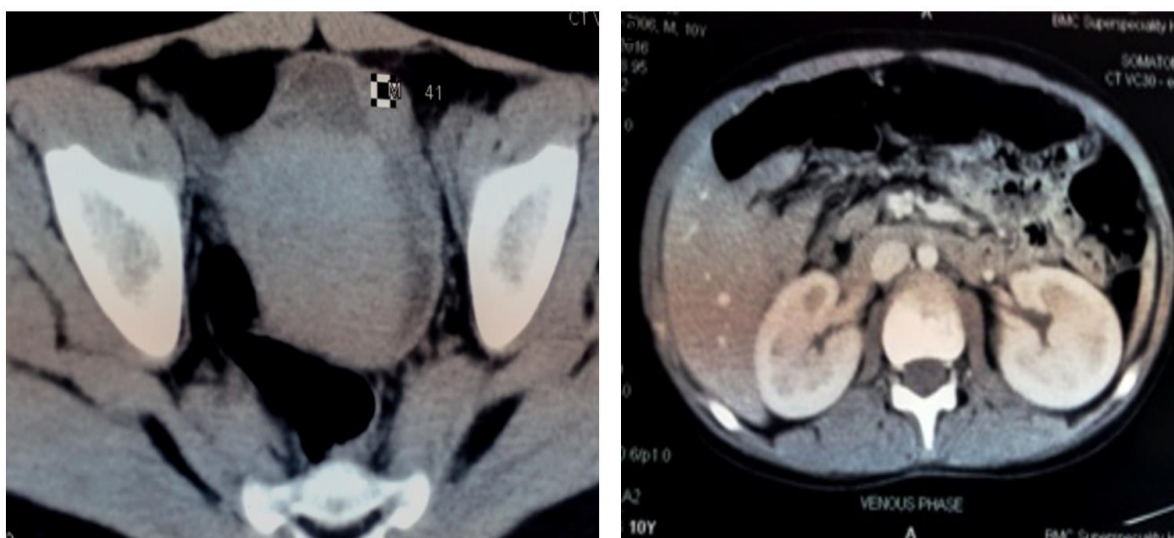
Contrast-enhanced computed tomography (CECT) of the kidneys, ureters and bladder. (A) Nodular wall thickening of the superior aspect of the urinary bladder measuring approximately 4×3 cm, showing minimal enhancement and raising suspicion of a neoplastic growth. (B) A well-defined hyperdense intravesical lesion measuring approximately 5×7 cm, consistent with a bladder clot. Both kidneys were normal.
